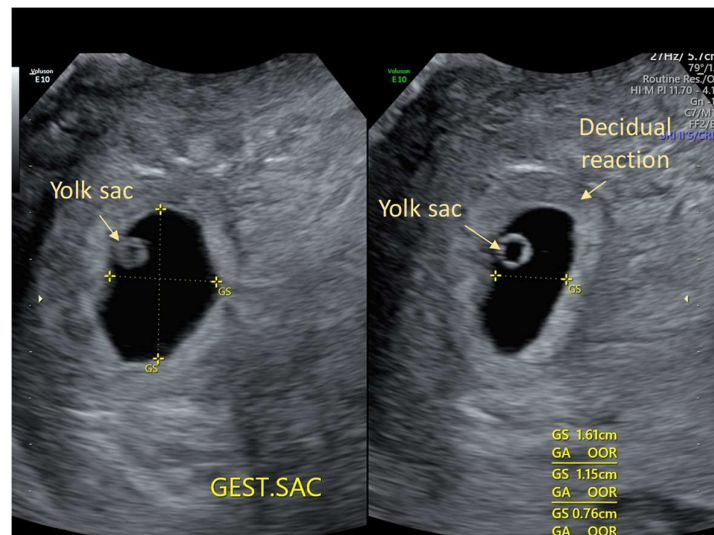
Gestation sac at approximately 5 weeks imaged with contemporary ultrasound equipment measured in three planes. The yolk sac is identified within the gestational sac and its walls are thick and more echogenic than the myometrium due to the decidual reaction. Note electronic 'on screen' calipers and measurements displayed and averaged (bottom right corner). Image produced by D Paoletti.
